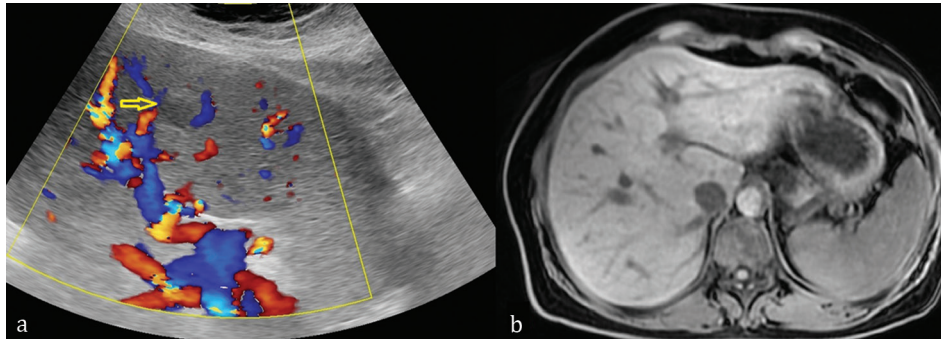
Splenic Gaucheroma: hyperechoic lesion with calcified perimeter: a) ultrasound imaging: hypo echoic focal lesion without Doppler signal and without mass effect; b) MRI imaging: no specific findings (besides slightly inhomogeneous aspect).
